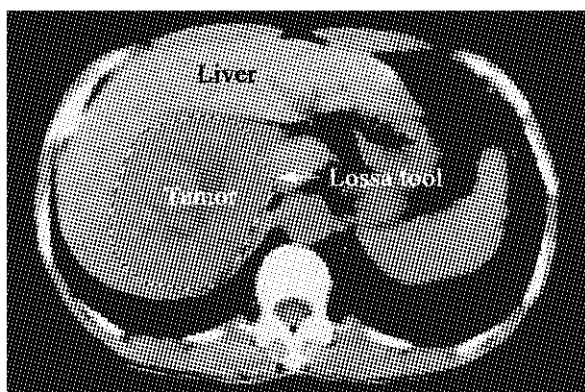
The JPEG image file of CT film is opened by PhotoShop. The edges of tumor were accurately margined by the lossa tool.
